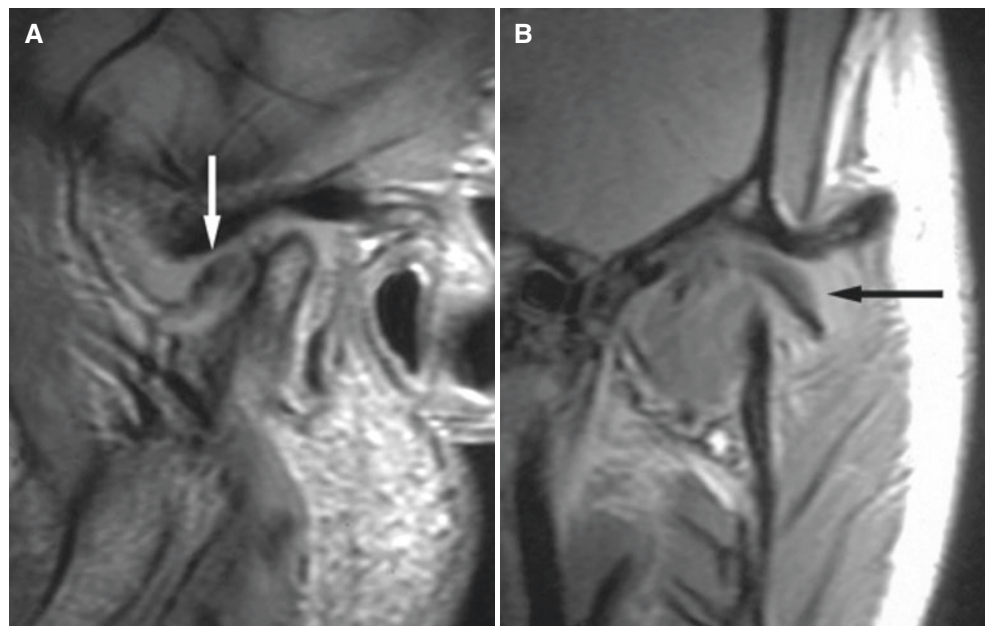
Osteoarthritis, posterior disc displacement. (A) Oblique sagittal MRI shows disc perforation and cortical irregularities of the condyle (*arrowhead*) and posteriorly displaced disc (*arrow*). (B) Oblique sagittal open-mouth MRI shows the disc (*arrow*) adherent to the condyle. Reproduced with permission from Westesson et al. (1998)
